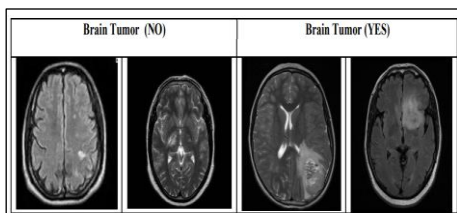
Brain Scans with MRI
